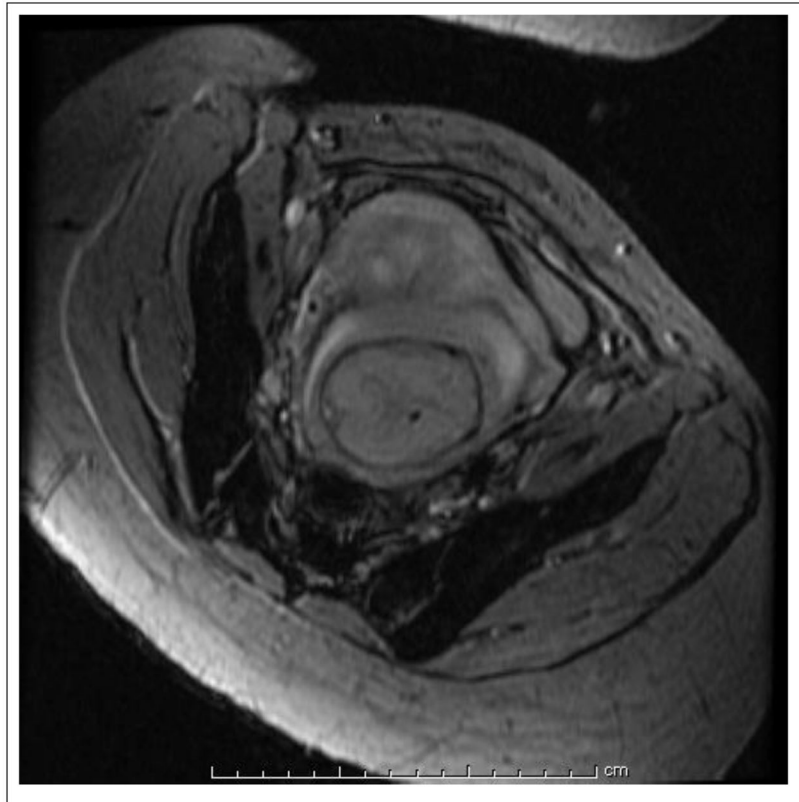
T2* weighted gradient echo sequence acquired as one in a 4 slice stack in 23 seconds using TR/TE/FA = 150/25/20, a 4 mm slice thickness, 1 mm gap, and a 256×128 (frequency × phase) matrix with a 46×30 cm² FOV. Note the periventricular hypointense lesion suspected to be blood (hemorrhagic lesion) with a short T2*. This lesion was subtle or not appreciated on SST2W, T1-weighted gradient echo, and SSFP sequences applied in this study.
